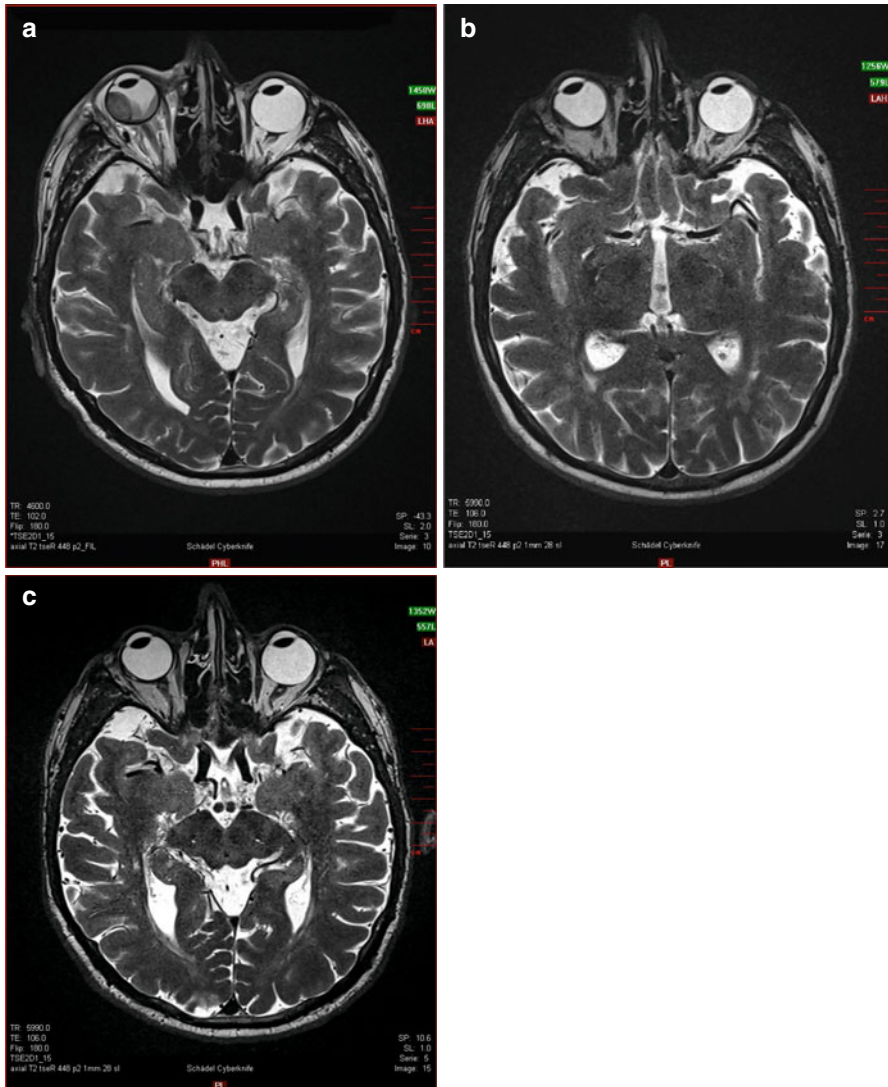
(a) T2 MRI sequence showing large Uveal Melanoma on the temporal right eye with associated retinal detachment. (b) Follow up after 9 months shows significant tumor volume reduction and reversible retinal detachment. (c) Follow up after 18 months displays complete regression of the melanoma
